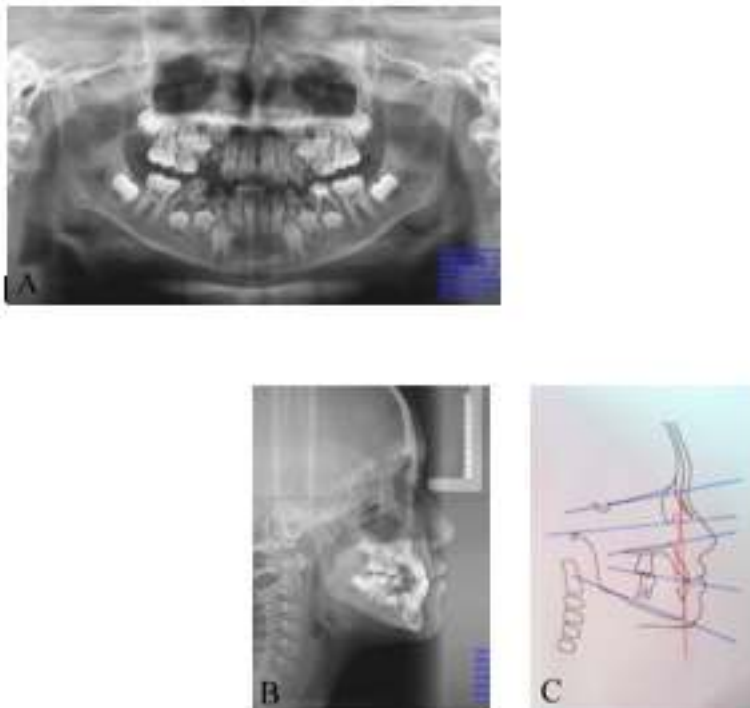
Radiograph Before Treatment. (A) Panoramic; (B) Cephalometric; (C) Cephalogram Analysis.
